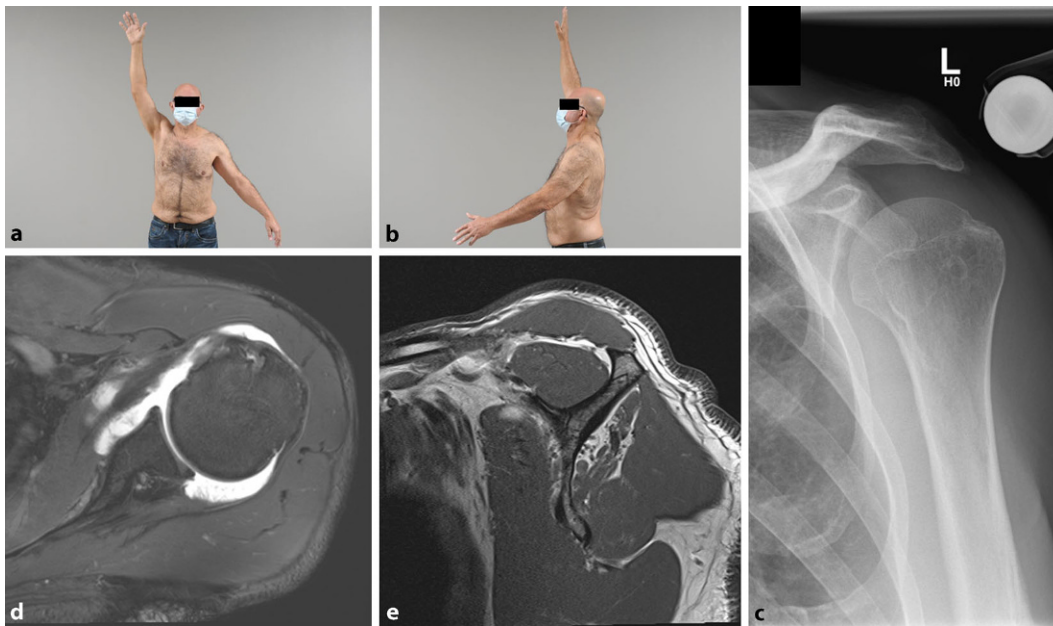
▲ Acute pseudoparalysis in a 67-year-old patient after a fall on his left shoulder with an acute subscapularis tendon tear and chronic infraspinatus tear. Limited active range of motion with a 30° of abduction and b 30° of anterior flexion. c Anteroposterior radiographs show no cranialization of the humeral head with an acromiohumeral distance of 10 mm. d Axial MRI slides show full-thickness subscapularis tendon tear with e no fatty infiltration of the subscapularis muscle and a chronic grade 4 infiltration of the infraspinatus muscle. This patient was treated with arthroscopic subscapularis tendon repair
